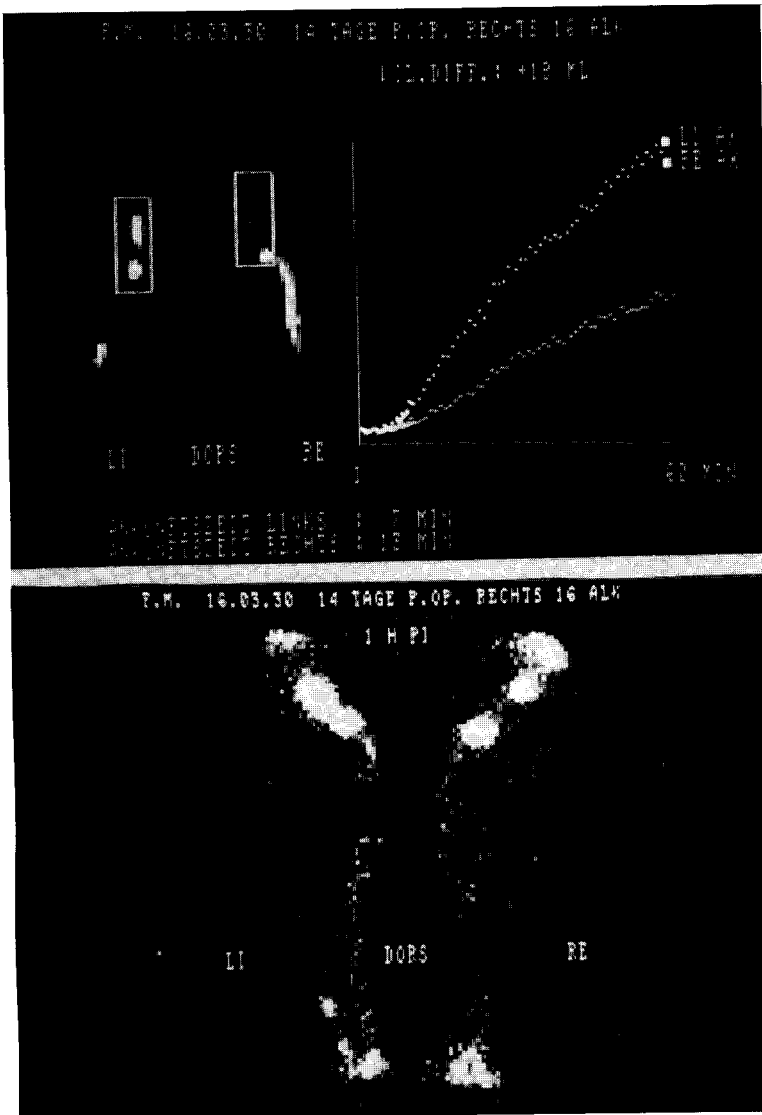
Dynamic and static lymphoscintigram 14 days after modified radical mastectomy. Note the decreased radioactive uptake in the right axilla (region of interest) during the first hour (above, upper right). Static images of arms (above, upper left) show distension of right arm lymphatics and decreased nodal uptake. Static images of forearms (below) show nearly normal distribution of tracer in lymphatics and orbital nodes (compare with Fig. 5).
